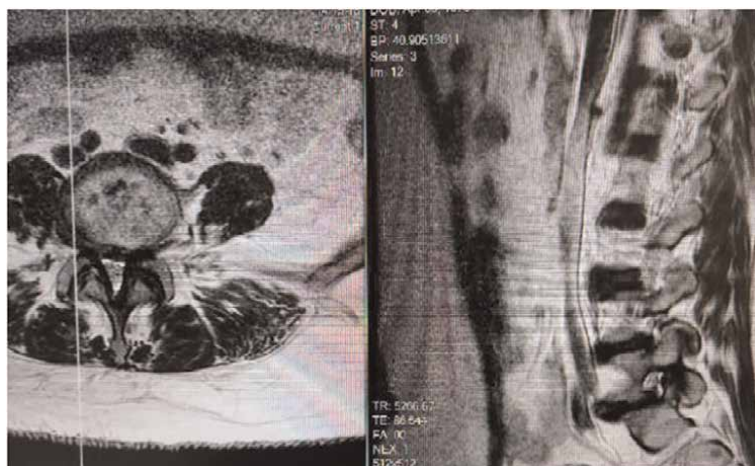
Right Parasagittal Lumbar MRI of Lumbar 45 demonstrates Severe neuroforaminal stenosis and central stenosis as a result of ligamentum flavum hypertrophy and facet joint hypertrophy.
